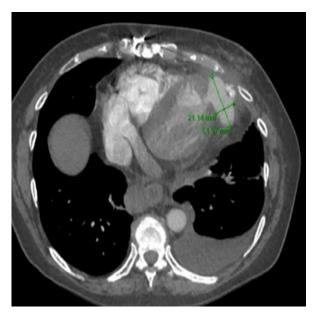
Preoperative computed tomogram with contrast medium shows the $2.1 \times 5.2 \times 2.2$ -cm pseudoaneurysm.
